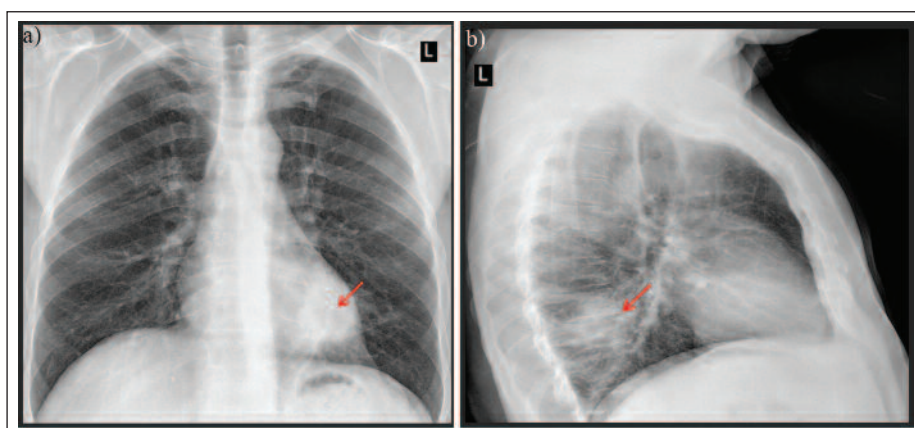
Chest radiographs: a) PA and b) LL view
